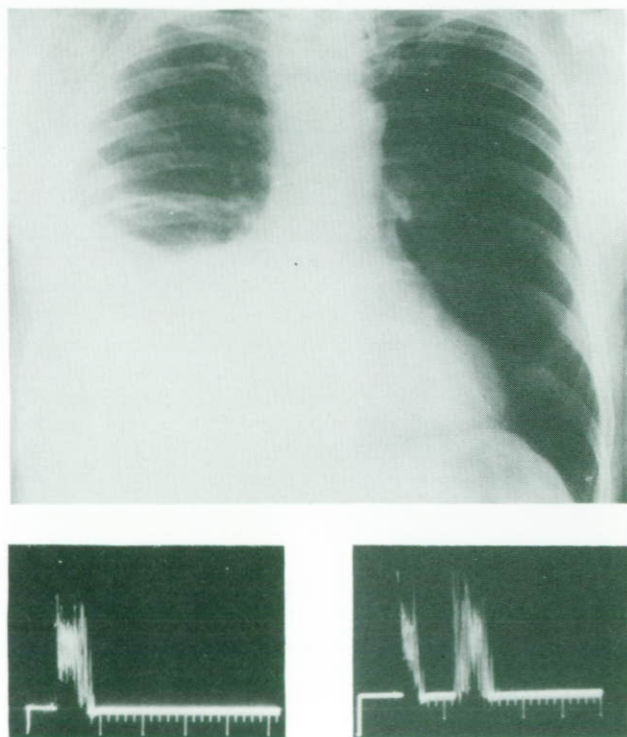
(A) Chest radiograph showing a right sided pleural effusion, confirmed by ultrasound. (B) Normal ultrasound appearance. (C) A clear echo-free zone demonstrates the presence of a pleural effusion.
